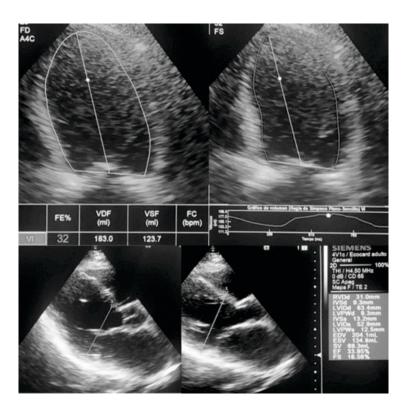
Echocardiogram one month after treatment. Presents an increase in FEVI to 33%. Additionally, it was found: TAPSE 20mm, E/e'15, PSAP 38mmHg.
